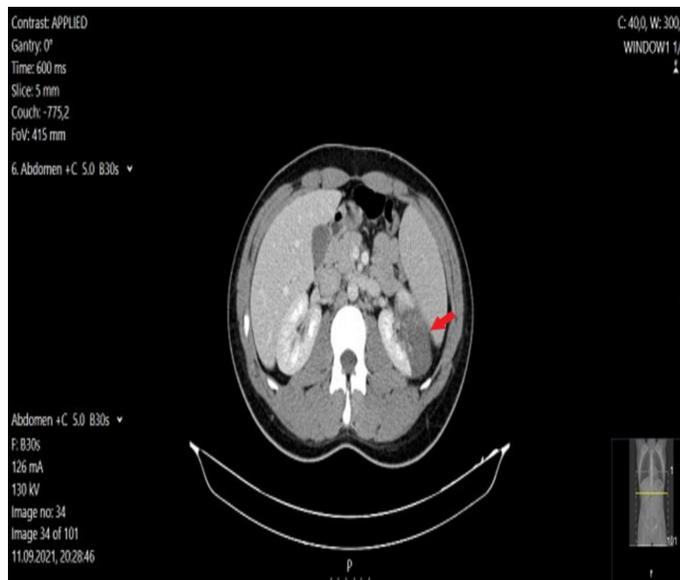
Contrast-enhanced abdominal computed tomography shows a patchy hypodense area in the cortical area in the upper pole of the left kidney
